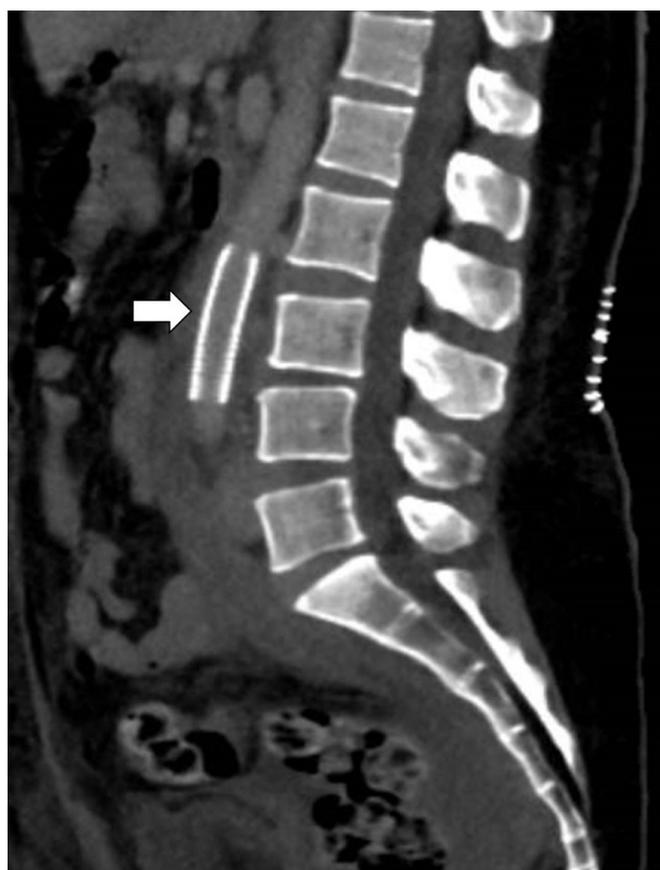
CT angiography performed after endovascular treatment showing a correctly placed aortic stent (arrow) at L3-L4 level.
